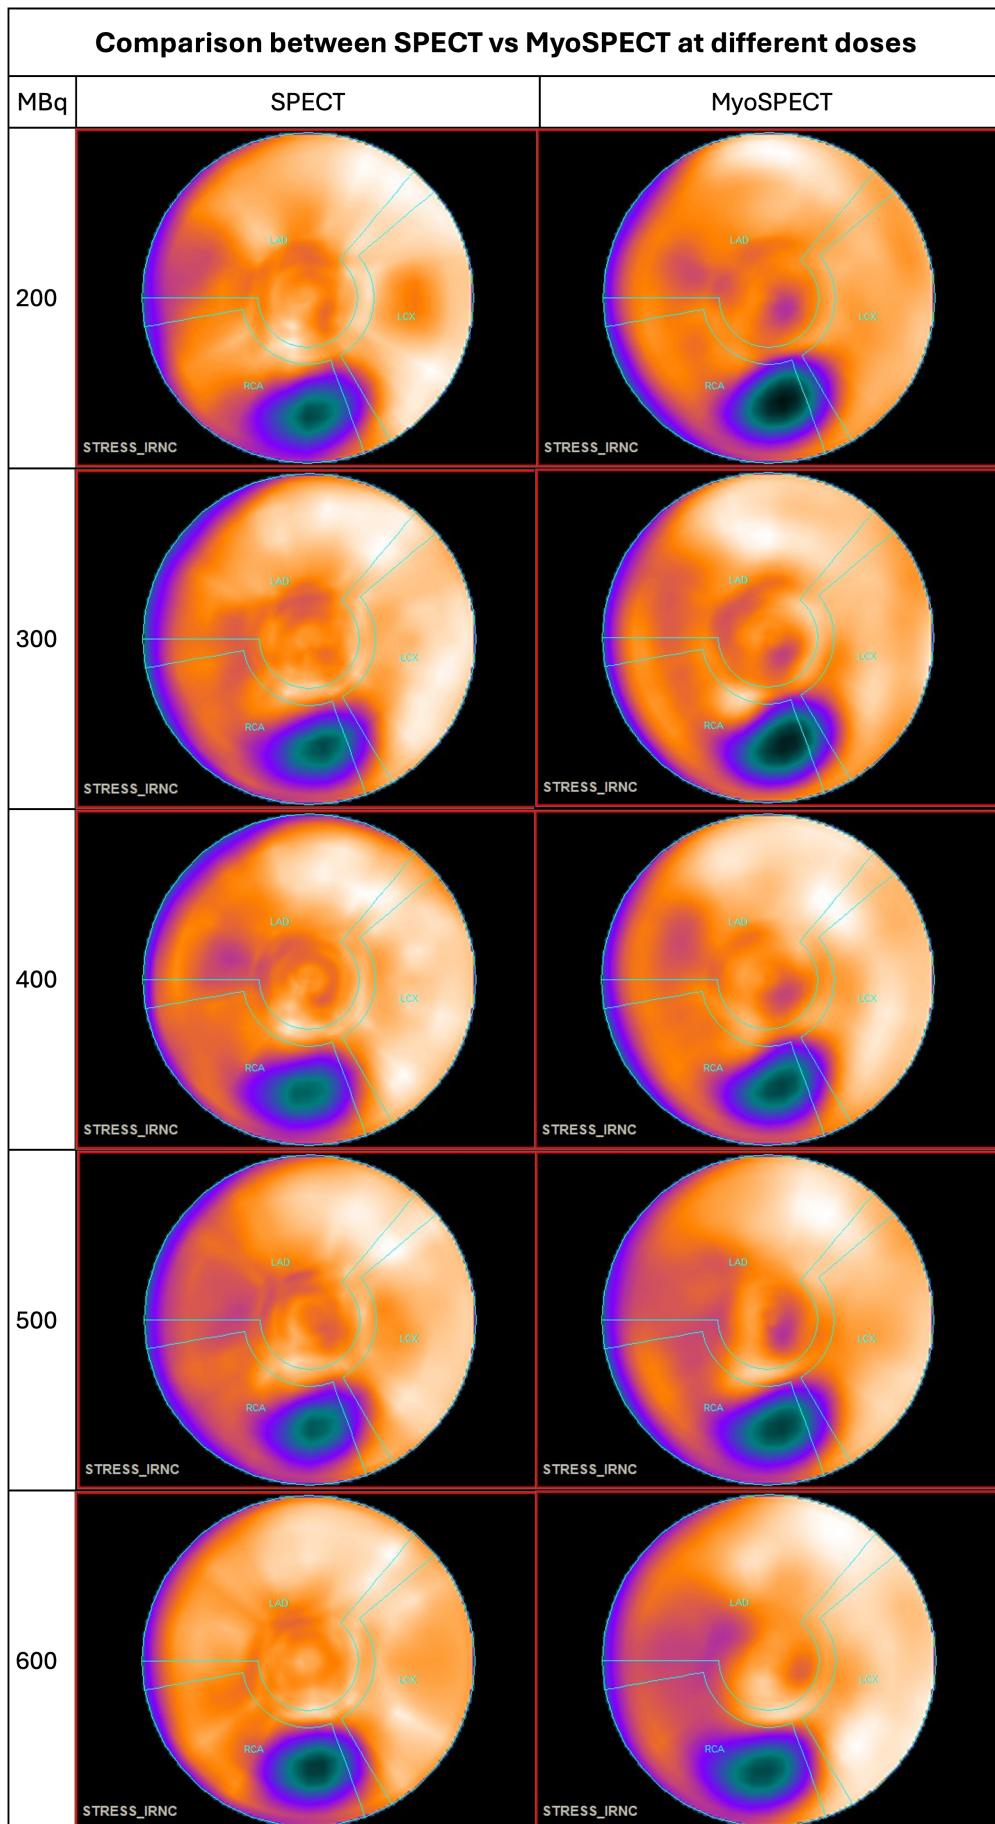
Comparison of SPECT and MyoSPECT through polar maps of the vessels
